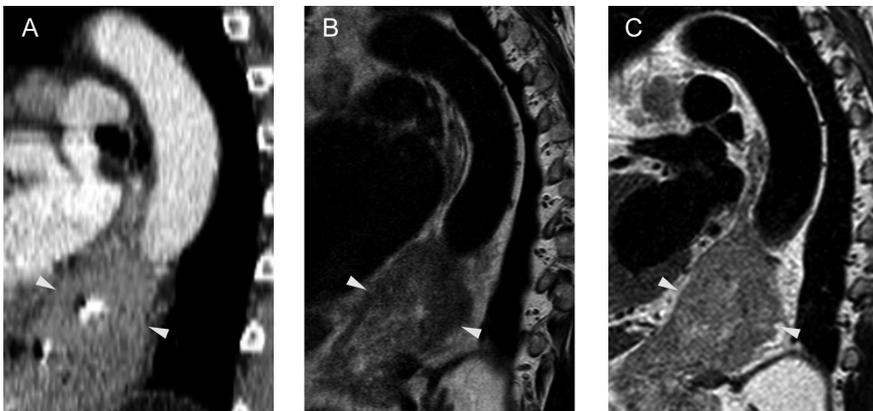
An example of improving MRI for esophageal cancer with cardiac triggering and breathhold in a patient with a cT3N3M1 (hepatogeneously metastasised) distal esophageal squamous cell carcinoma (*arrowheads*). A) Standard sagittal planning CT image, acquired for radiotherapy purposes. B) Normal sagittal T1W 1.5-T MR image of the chest without motion gating. C) Similar sagittal T1W 1.5-T MR image in the same patient after applying cardiac triggering and breathhold.
